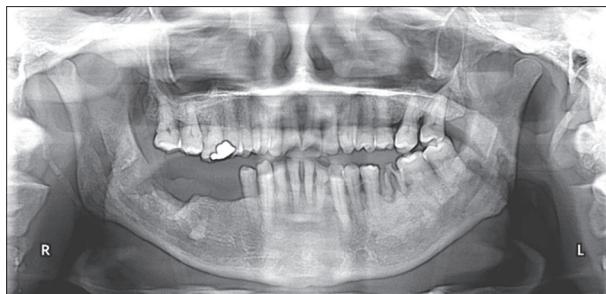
Orthopantomogram showing a large lytic lesion involving the right posterior mandible with erosion of the cortex
